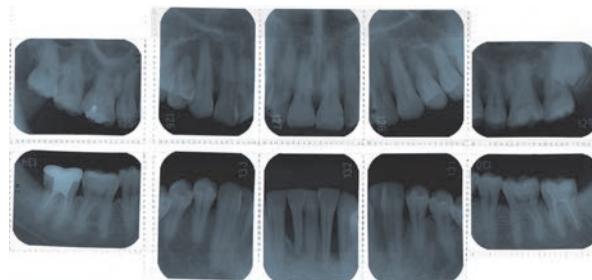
X-ray graph on August 2014
